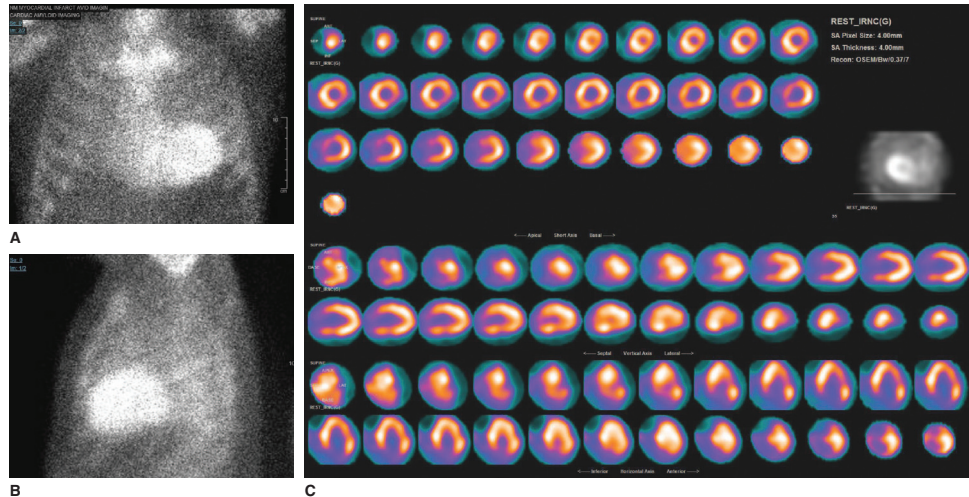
Tc-99m PYP scan showing qualitative Grade III uptake on planar images (A and B) with confirmation of myocardial tracer retention on (C) SPECT imaging consistent with a diagnosis of ATTR cardiomyopathy.
